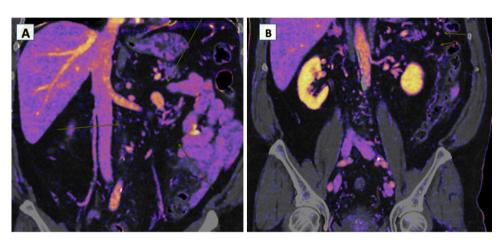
Angio CT scan with color subtraction imaging showing a reduction of venous vascular engorgement (a coronal view) and a significant regression of parietal thickening of the sigmoid colon (b axial view)
